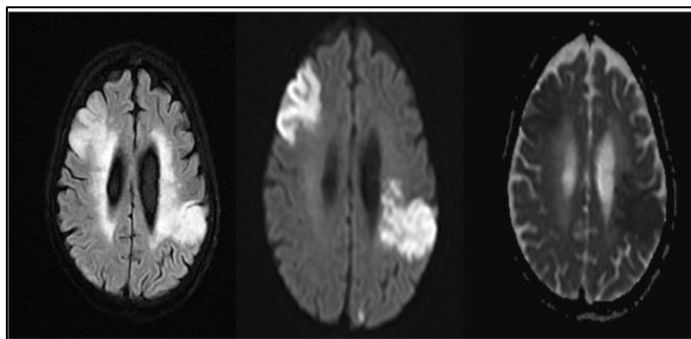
T2 / FLAIR, DWb1000, ADC
